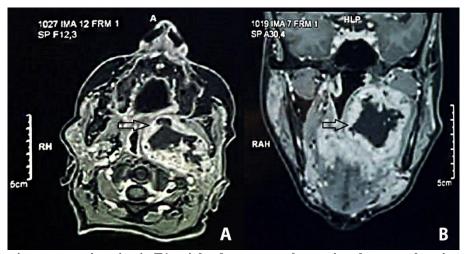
Magnetic resonance imaging in T1 weighted sequences showcasing the tumor location and extents (A: axial cuts passing through the level of the soft palate, B: coronal cuts passing through the level of the ramus)
